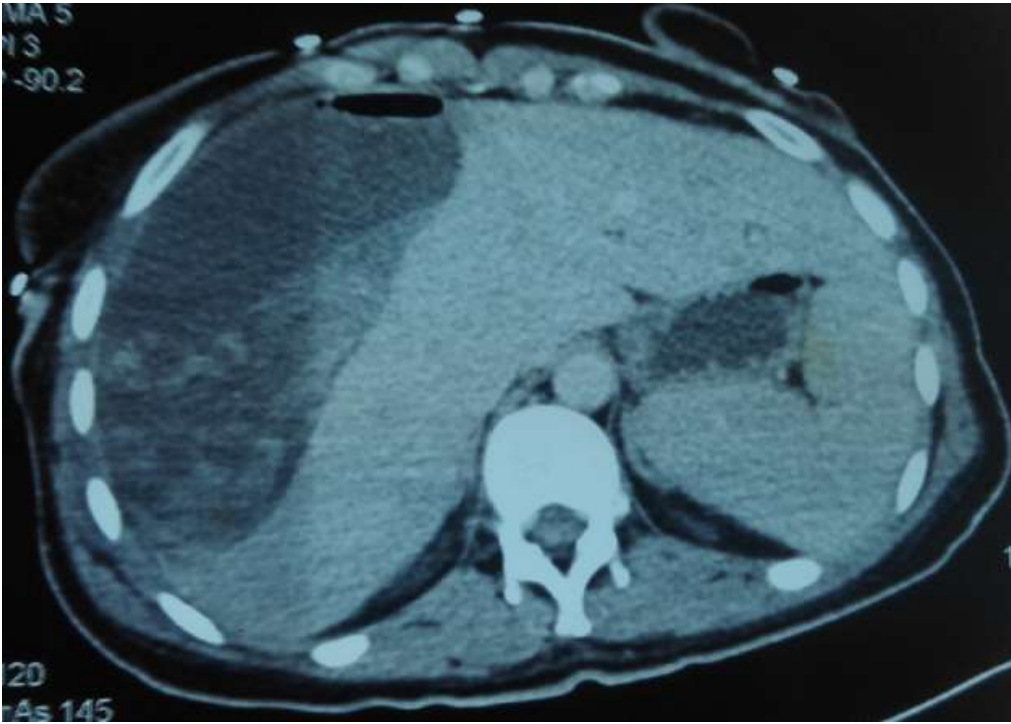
computed tomography (CT) image showing large subcapsular hepatic hematoma (8-16 cm) in maximum dimensions with air inside, following (ERCP)
